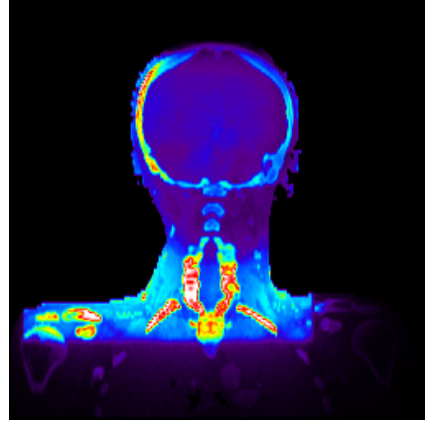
Isocentric slices for Pat. A for a single beam at 0° . The slice positions are marked in the CT-slices shown in (n) - (p).
